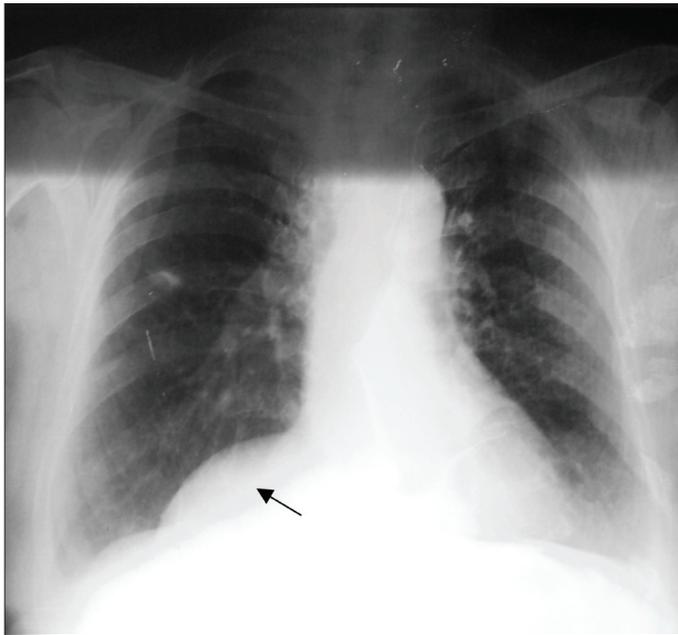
Chest X-ray view of right-sided diaphragmatic elevation
